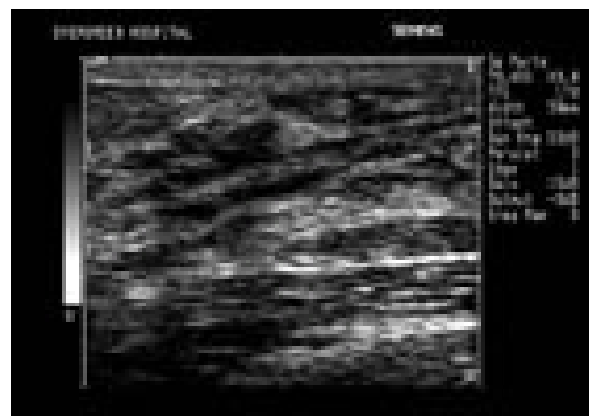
Sonogram of Normal Breast Fat Tissue [Image courtesy: www.google.com/normal breast sonogram]
